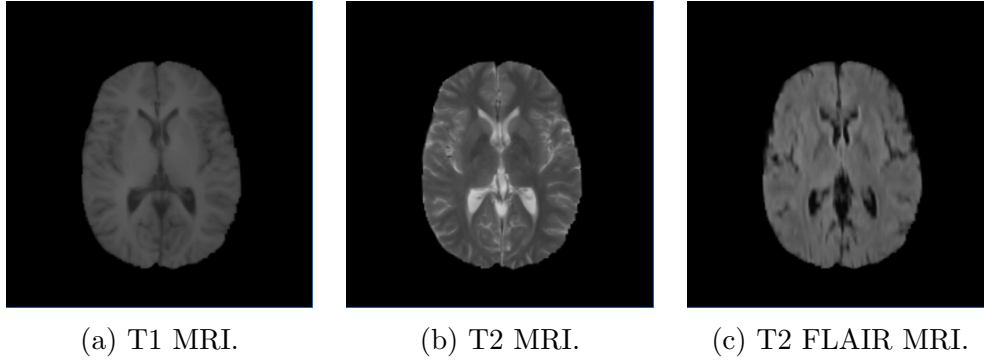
T1, T2, T2-FLAIR images.
